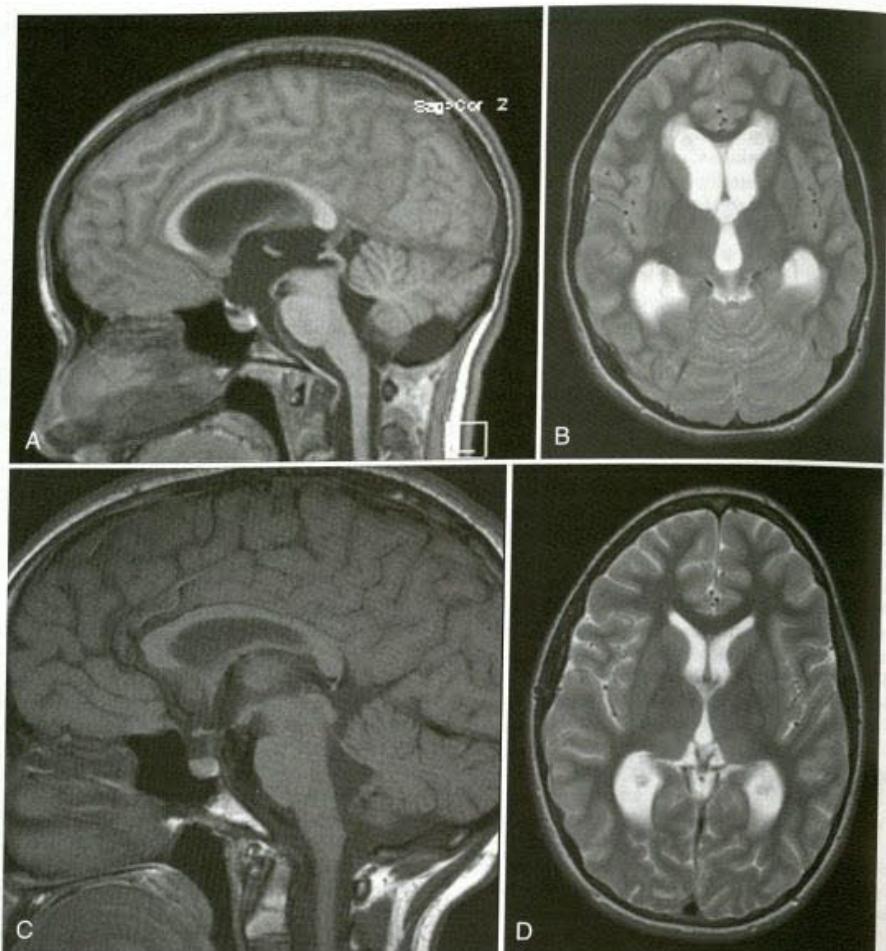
Noncommunicating hydrocephalus in a child with aqueduct stenosis undergoing endoscopic third ventriculostomy. A, Preoperative T1 sagittal magnetic resonance image (MRI) showing stenosis of the caudal aqueduct with inferior bowing of the third ventricular floor and a retrocerebellar cyst. B, Preoperative T2 axial MRI showing enlargement of the lateral and third ventricles. C and D, Postoperative T1 sagittal MRI and T2 axial MRI showing resolution of ventriculomegaly.
